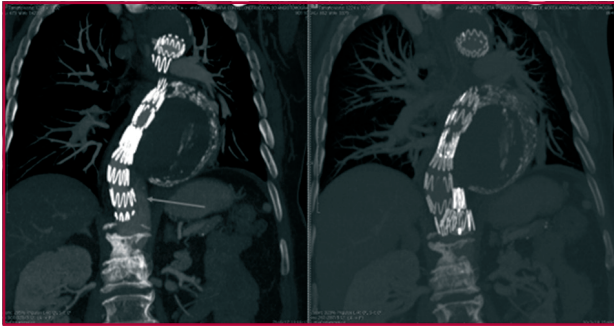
Preoperative (left) and postoperative (right) computed tomography scan image with evidence of flow in the distal false lumen (red arrow), which disappears after placing the plug.
